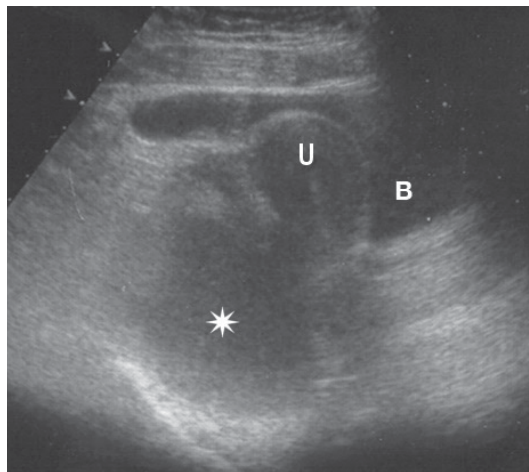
Ultrasonography. Transabdominal approach. A moderate amount of corpuscular liquid can be seen in the rectouterine pouch. *U*, uterus. *B*, urinary bladder
